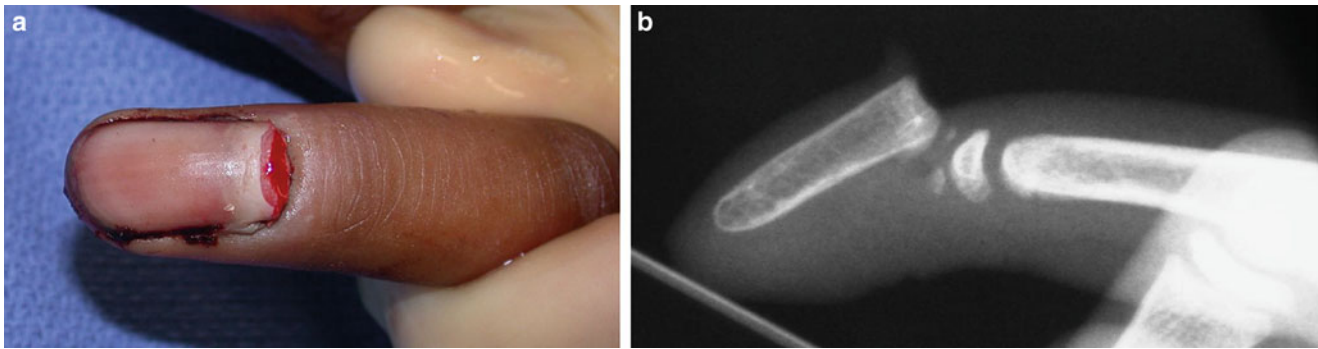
Seymour fracture. (a) Avulsed nail plate resting superficial to proximal nail fold. (b) Lateral radiograph showing angulated fracture involving the physis of the distal phalanx
